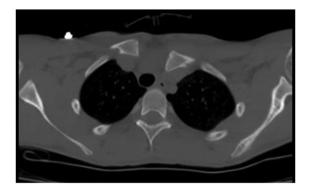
Axial CT scan taken at the time of injury showing left posterior SC joint dislocation. *CT*, computed tomography; *SC*, sternoclavicular.
